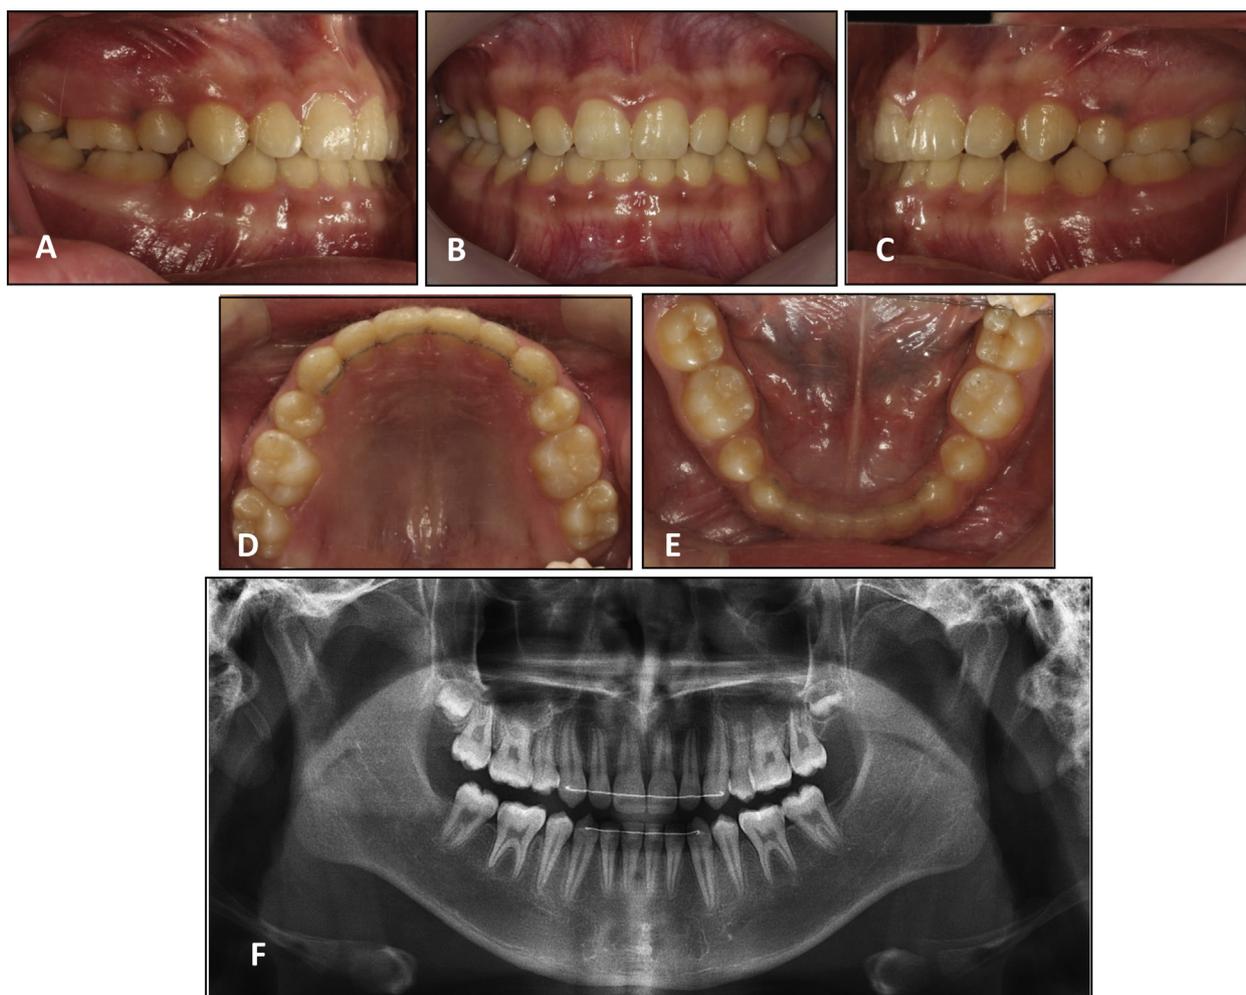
Posttreatment intraoral photos and panoramic radiography showed Class I molar key and functional occlusion. Total active treatment period was 43 months. Radiographic evaluation shows sufficient root length with no periodontal problem or pulp resorption.
